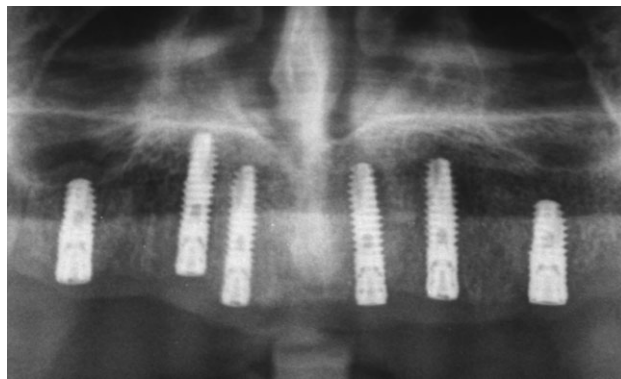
Initial radiographic situation after implant placement.
